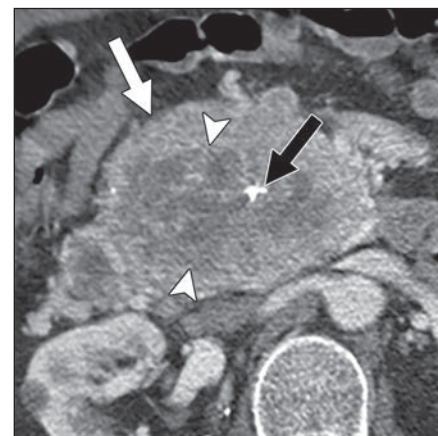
48-year-old man with alternative lengthening of telomeres (ALT)-positive pancreatic neuroendocrine tumor. Arterial phase contrast-enhanced CT image shows enhancing mass (white arrow) with central necrosis (arrowheads) and calcification (black arrow) arising from pancreatic head.
